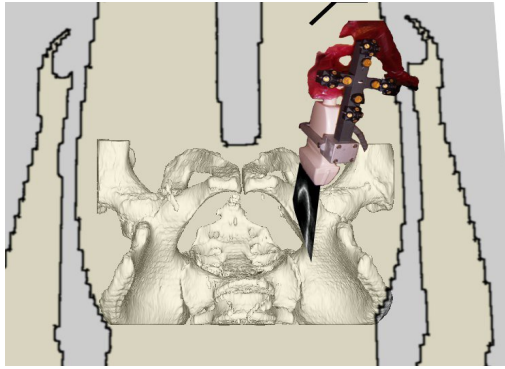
A series of ultrasound images of the patient's pelvic bone are collected in theatre. The position of these in the theatre are determined using an optical tracking system to track a group of infrared emitting diodes attached to the probe.
